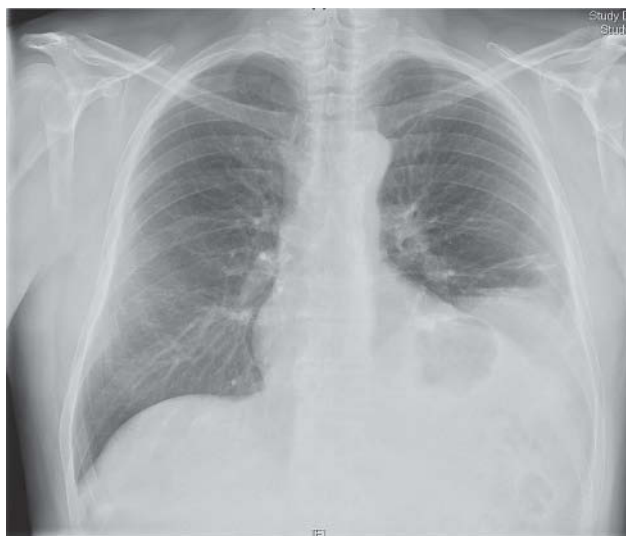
PA chest x-ray showing elevation of the left hemidiaphragm.
